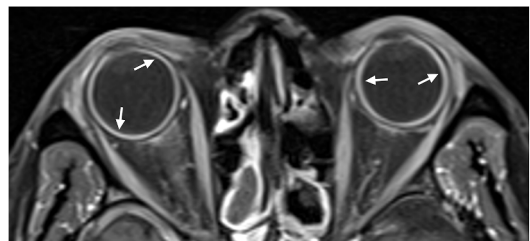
Axial fat-suppressed gadolinium-enhanced T1-weighted MR sequences of a 52 year old woman with bilateral panuveitis and a history of Behcet's disease. There is diffusely thickened uvea with marked enhancement bilaterally (*white arrows*).
